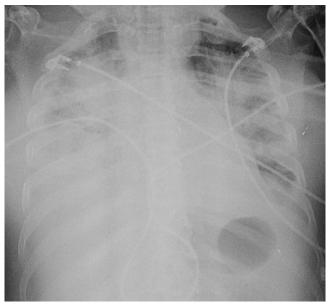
Alveolar hemorrhage seen on chest X-Ray after massive hemoptysis on day 2 following intubation
